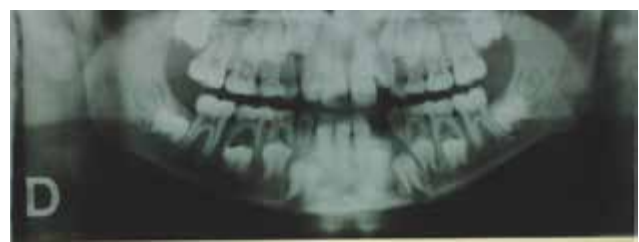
First radiogram of a x-rays series taken annually to monitor tooth eruption after surgical removal of the odontoma.
